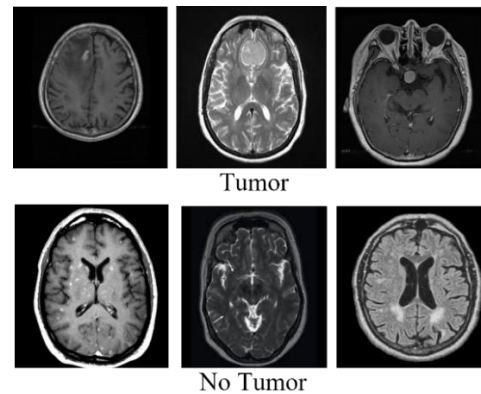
The example of brain tumor MRI images and no tumor
